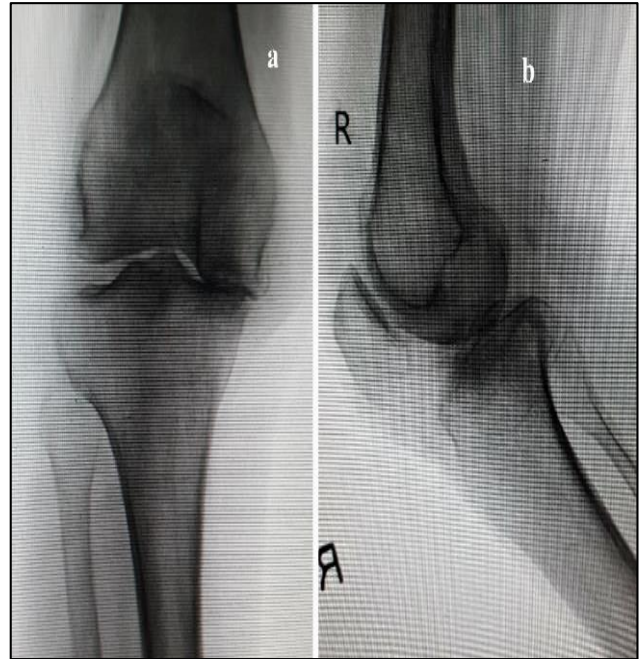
(A and B): Antero-posterior view in standing posture and lateral view radiograph of the right knee with advanced degenerative osteoarthritis.
